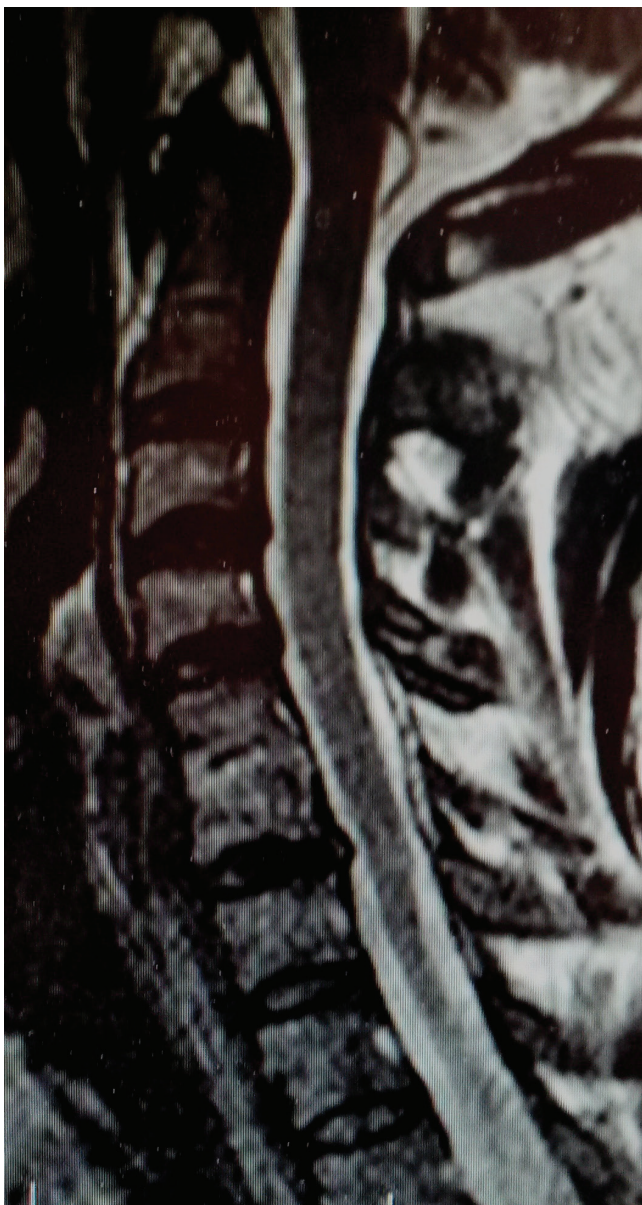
Preoperative sagittal T2-weighted magnetic resonance imaging (cervical 6-7 hernia nucleolus pulposus, cervical 5-6 fusion)
